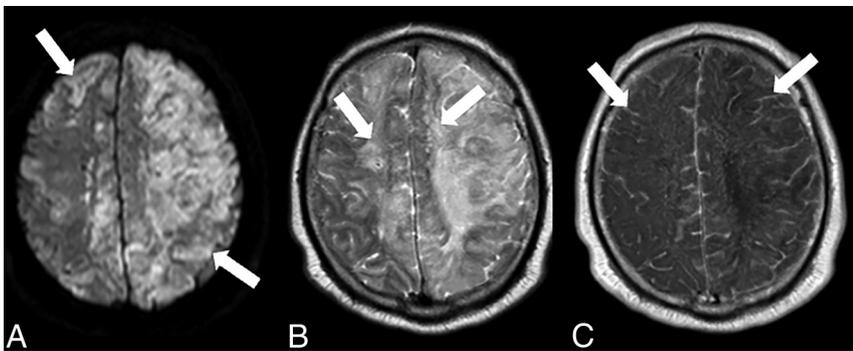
A 68-year-old man with symptoms suspicious for CAE. Contrast-enhanced brain MRI demonstrates a mixed pattern of cytotoxic (*white arrows*, DWI sequence, A) and vasogenic edema (*white arrows*, T2-FLAIR sequence, B) in a distal vascular bed distribution, with associated leptomeningeal enhancement adjacent to regions of edema (*white arrows*, postcontrast [MultiHance; Bracco Diagnostic] 2D spin-echo T1 sequence, C). CTA of the head and neck was notable for pneumomediastinum with gas interposed between the esophagus and left atrium (not shown). The findings were consistent with acute air emboli from a post cardiac ablation atrial-esophageal fistula.
